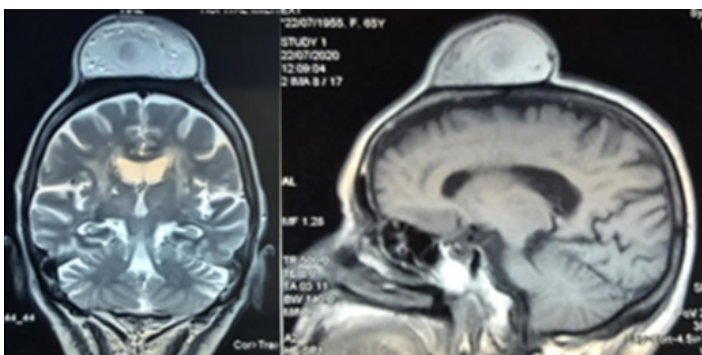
Brain MR imaging study showing frontal soft tissue lesion compatible with extra-cranial scalp arteriovenous malformations.
